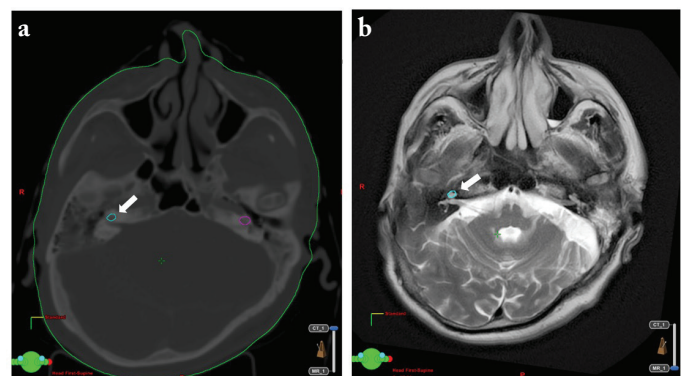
Contour of the cochlea on computed tomography and T2-weighted magnetic resonance imaging. a. The contour of the cochlea on computed tomography (white arrow). b. The contour of the cochlea on T2-weighted magnetic resonance imaging (white arrow)
